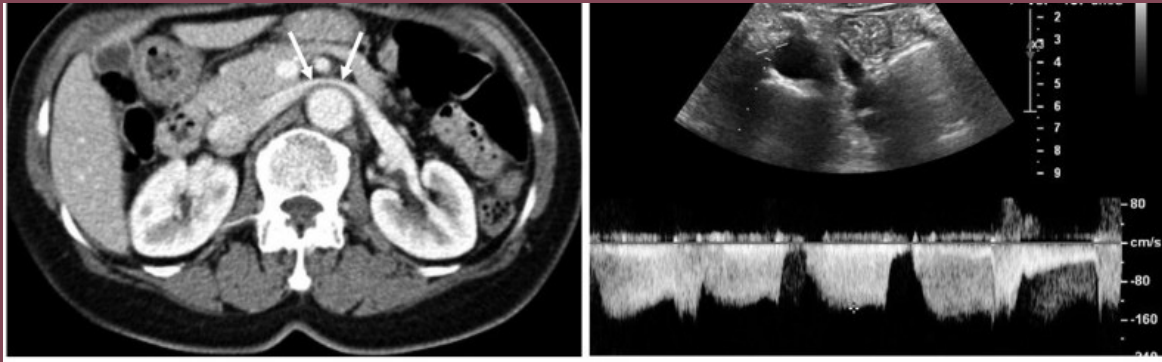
Renal vein compression at the aorto-mesenteric point as demonstrated by CTA (A) and Doppler Ultrasound (B).<sup>11</sup>
